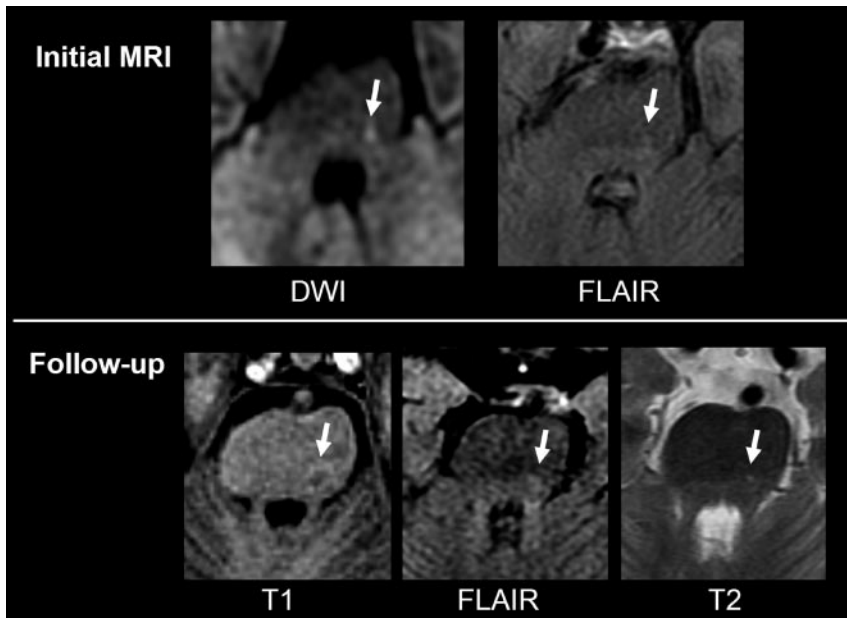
A 63-year-old man with a right sensory deficit for 10 hours. Initial MR imaging (63 hours after onset) demonstrates a focal DWI and FLAIR hyperintensity in the left brain stem (*arrow*). On follow-up MR imaging (6 months after onset), a small permanent injury can be seen as a dark signal intensity on T1-weighted sequence and a bright signal intensity on FLAIR/T2-weighted sequence in the corresponding area.
